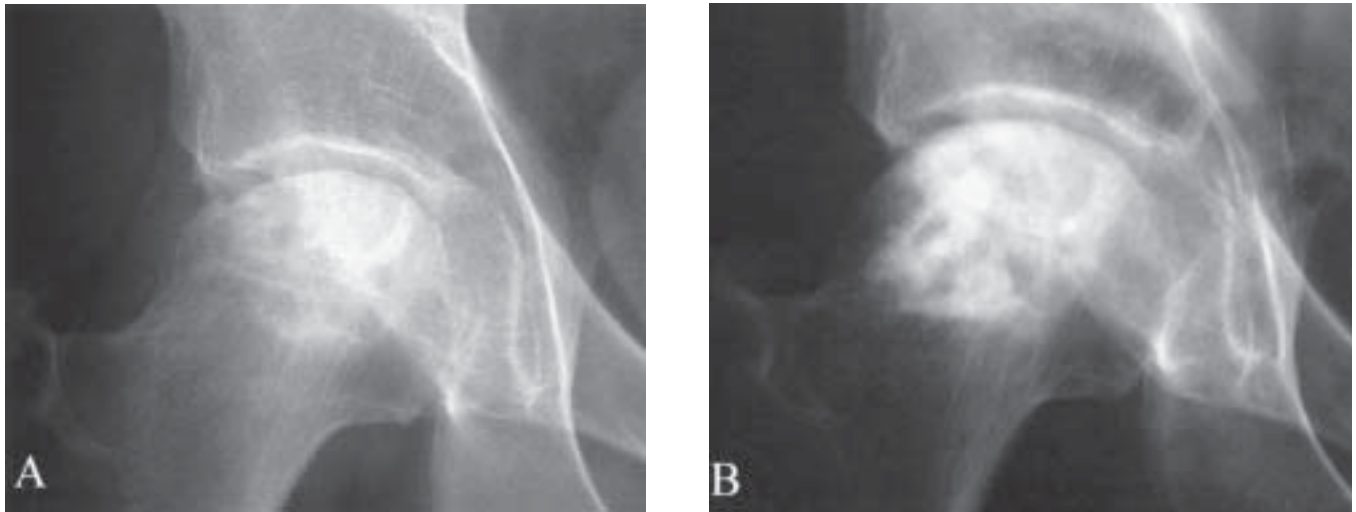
Pre- and post-operative radiographs demonstrating collapse (A) and restoration of femoral head sphericity with cementation (B).
